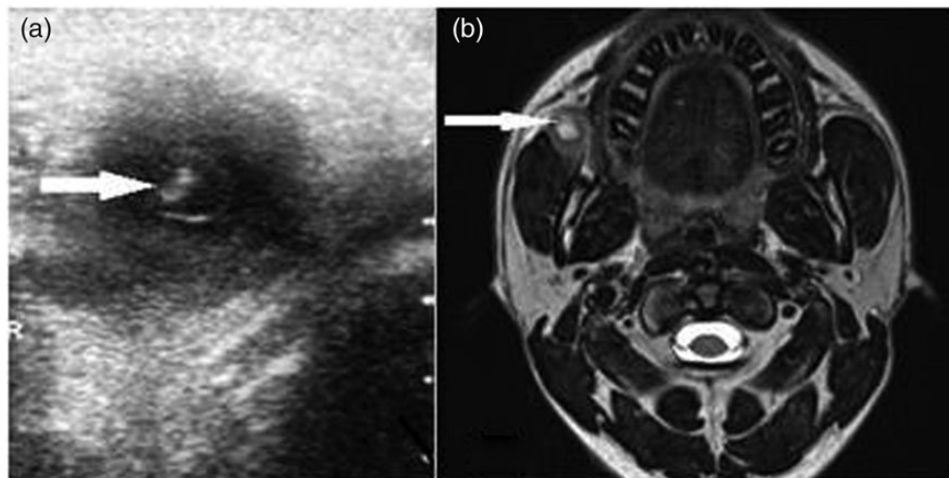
(a) USG image. Arrow showing an anechoic lesion with the scolex inside. (b) T₂-weighted MR image. Arrow showing a hyperintense lesion in the bucco-masseteric region.
